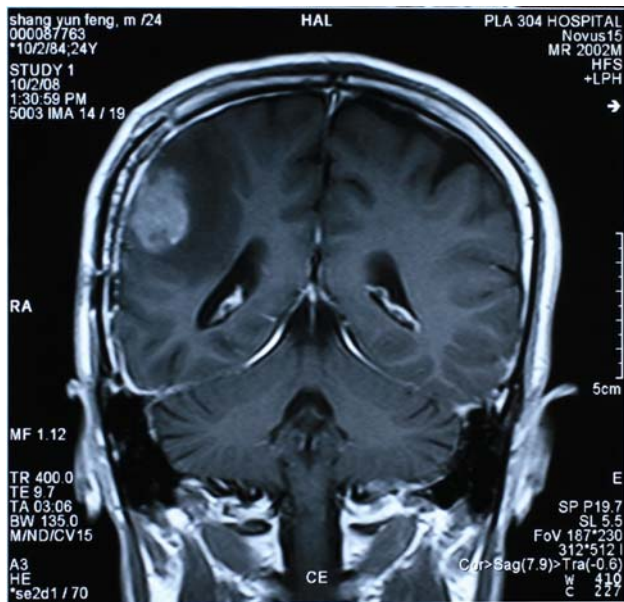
Gd-enhanced coronal T1-weighted MR images of the brain before the second operation revealing a recurrence at the location of the first operation with patchy surrounding edema
